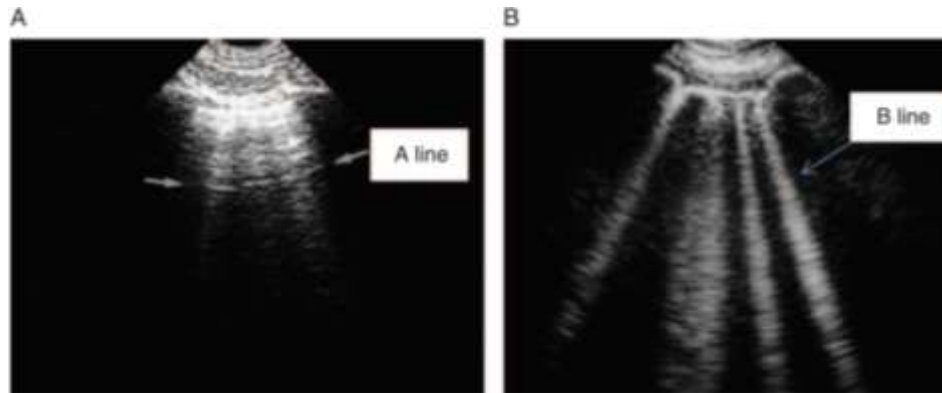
Lung ultrasound in normal and AHF patients. (A) From the pleural line, one repetition of the pleural line, a horizontal line [A line], parallel to the pleural line, is visible, indicating normal lung with no pulmonary edema. Arrows indicate A lines. Note some ill-defined vertical comet-tail artifacts, not to be confused with B lines. (B) Four or five B-lines arise from the pleural line. B lines are vertical, long, well-defined artifacts erasing the A-lines and moving in concert with lung sliding. B lines indicate pulmonary edema. Source: Whole Body Ultrasonography in the Critically Ill, Springer 2010.
